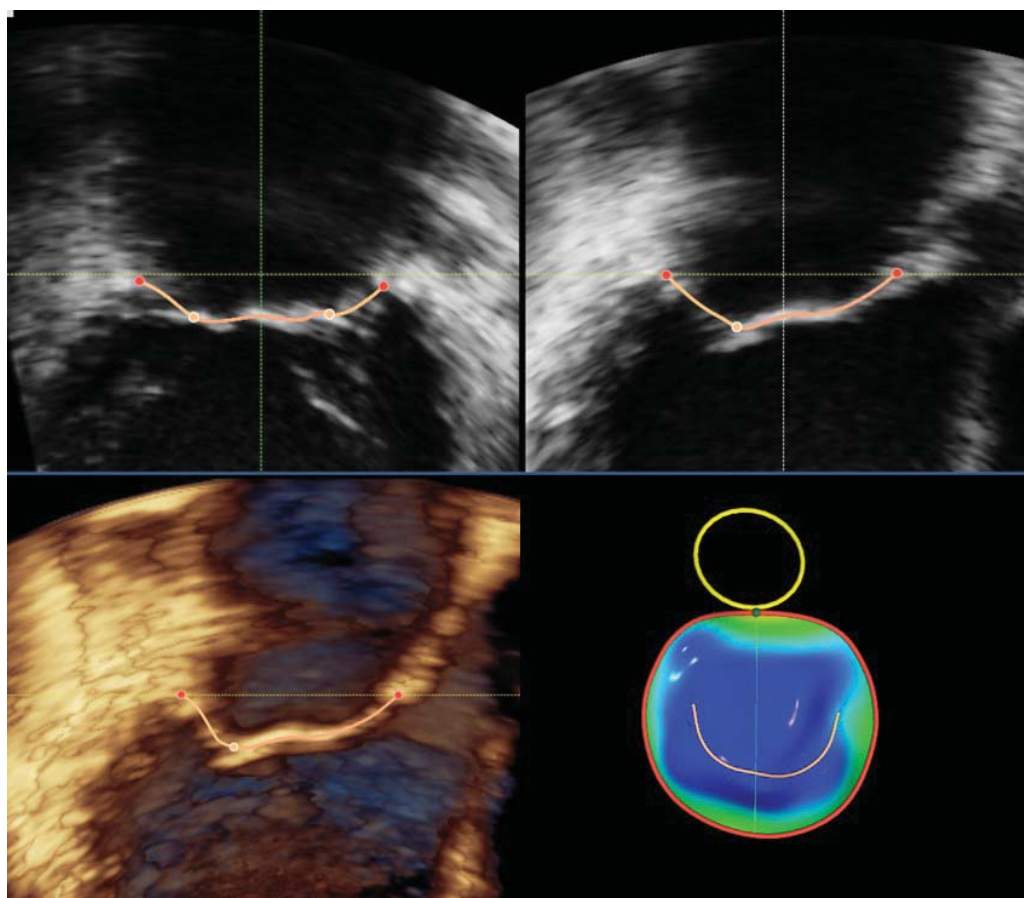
Transesophageal three-dimensional surface rendering display of the mitral valve. This display modality is obtained by semiautomated mapping of the leaflet surface and annulus contour in order to provide a quantitative analysis of the mitral valve annulus and leaflets using dedicated software packages.
